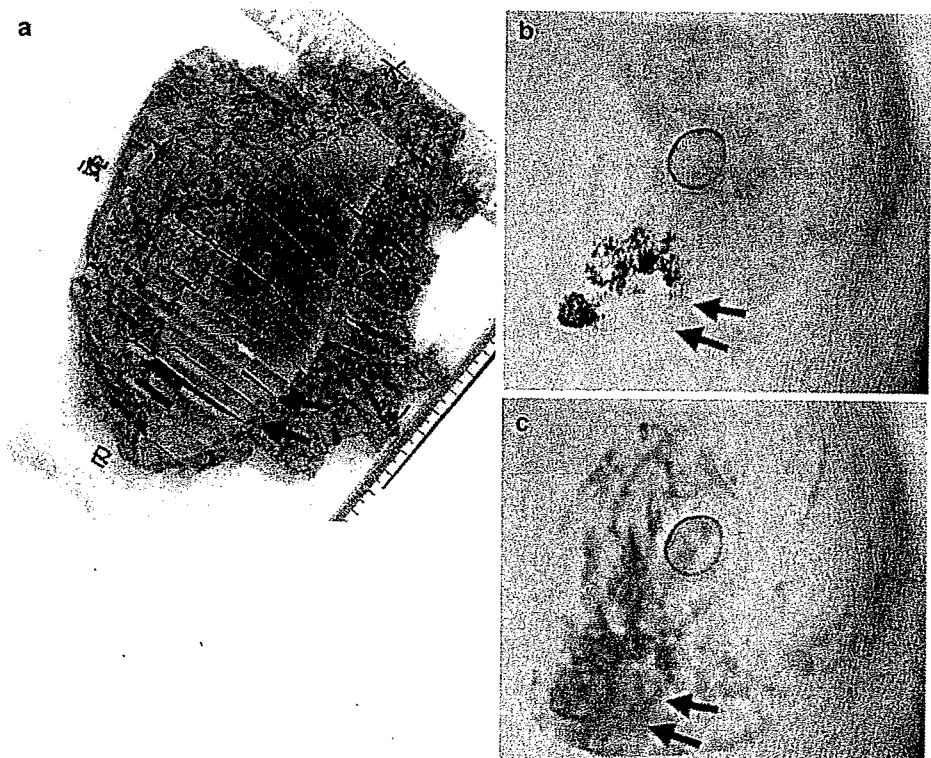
A 45-year-old woman with invasive ductal carcinoma of the breast. a Image showing resected tissues only. *Red lines* tumor invasion. *Green lines* lesion with ductal spread. b Three-dimensional CT image in the early-enhancement phase (generated by the volume-rendering method). The intraductal component extending from the main tumor toward the nipple is depicted; the extent of tumor tissue on the right side of the tumor mass is not depicted (*pink arrows*). c Perfusion map image. The tumor tissues (including the ductal spread extending to the right of the main tumor that could not be depicted in the early-enhancement phase) are clearly depicted (*pink arrows*), showing good agreement with the pathology findings
